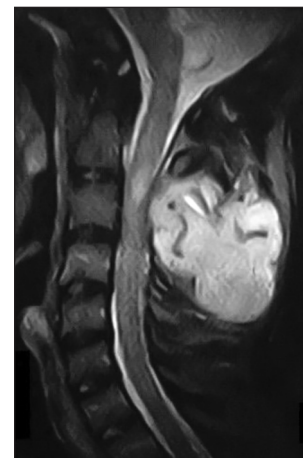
Postcontrast sagittal magnetic resonance image showing the cervical tumor to cause epidural compression, and a hyperintense signal is noted in the cervical cord
